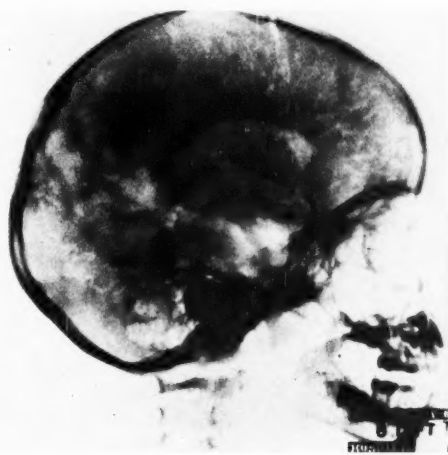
Lateral projection, left side down. Note the irregular width of the subarachnoid channels, described as studding. This patient was mentally defective, a suspected case of aplasia. No other x-ray evidence was shown, except the studding and the 24-hour bubbles.
